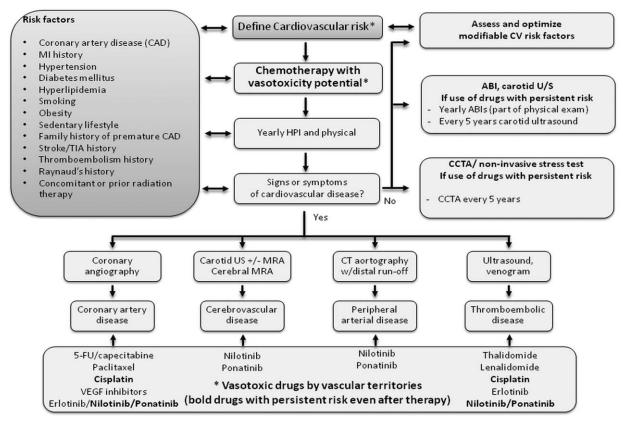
Suggested SCAI algorithm for the cardiovascular screening of patients on chemotherapy. HPI, history of present illness; TIA, transient ischemic attack; ABI, ankle-brachial index; U/S, Ultrasound; CCTA, cardiac computed tomography angiography. *Pivotal to the sequence is the determination of baseline cardiac risk, including presence of ischemic heart disease, history of myocardial infarction, cardiovascular risk factor profile, and calculated atherosclerotic cardiovascular disease risk, for example, AHA/ACC ASCVD risk calculator, Framingham risk score, or ESC Score.
